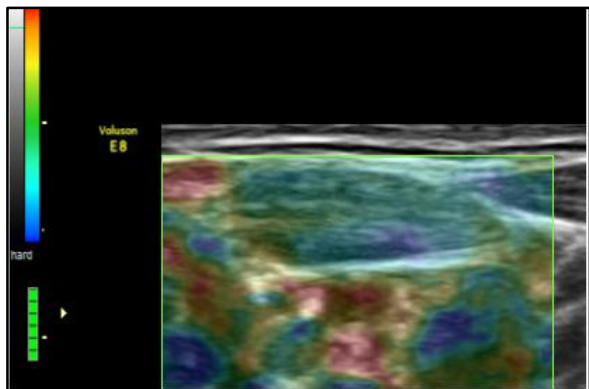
(a) Transverse sonogram of left level II cervical lymph node in a 53-year-old man, B-mode on the left showed score of 4, (b) Elastography showed pattern 2 (score 4) suggestive of benign lymph node.
